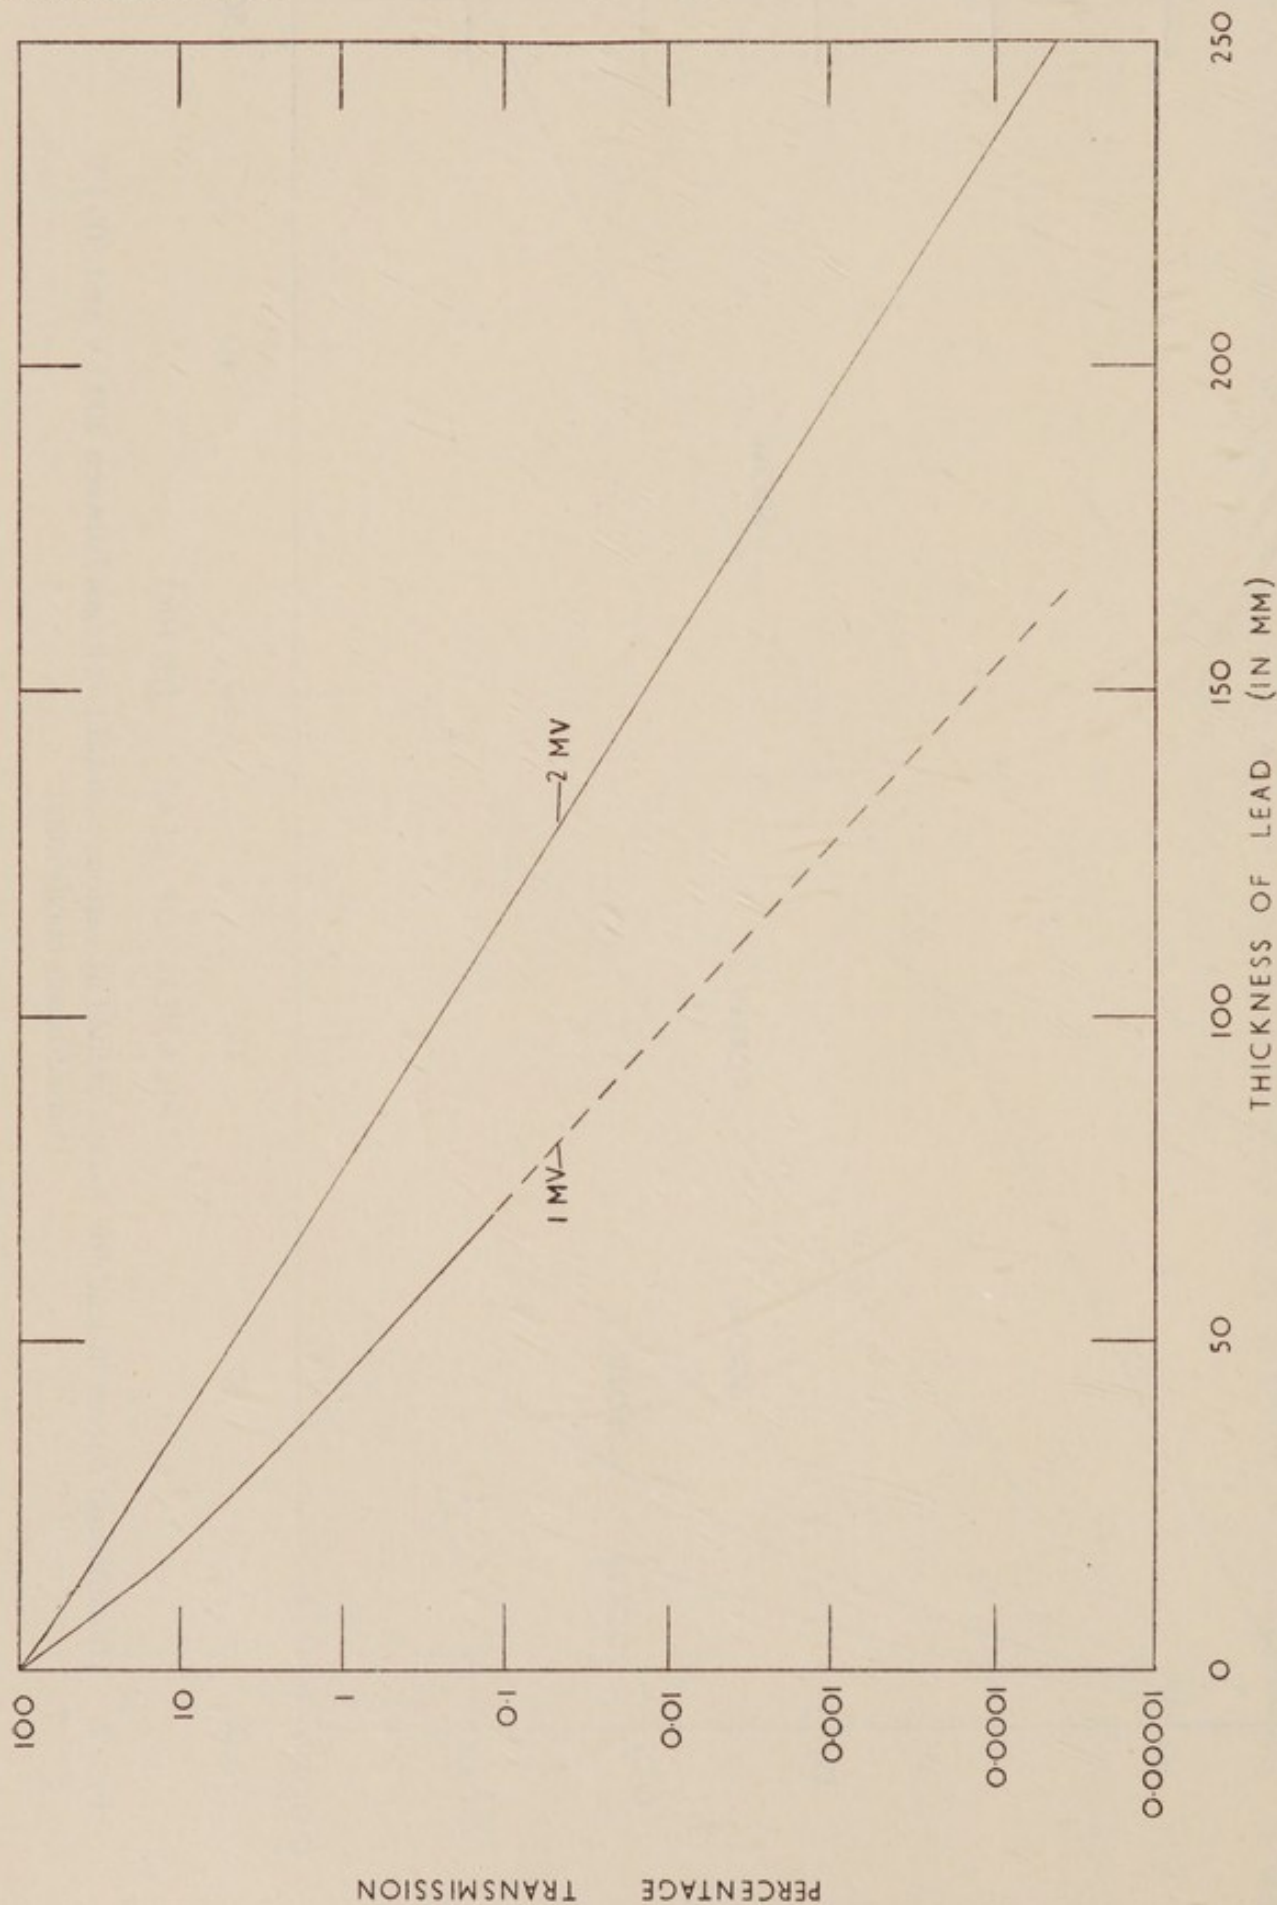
Transmission curves in lead for X-rays excited at constant voltages of 1 MV and 2 MV (broad-beam conditions).
